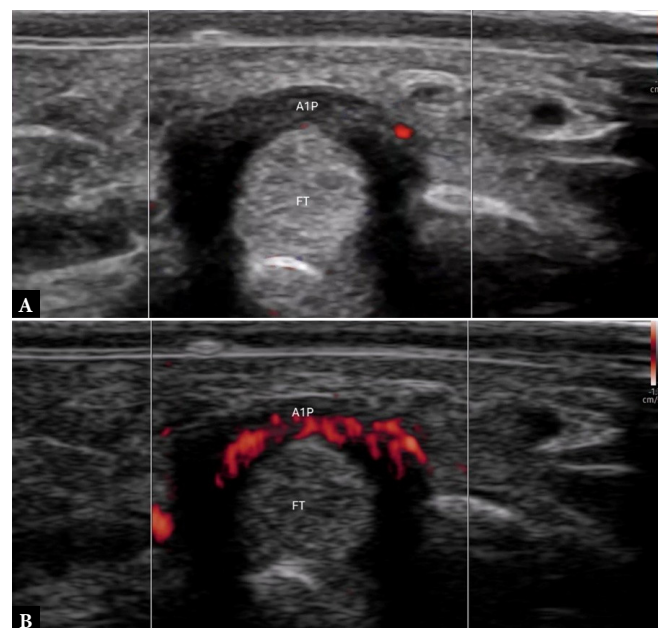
Trigger finger. Short-axis US scan of flexor tendons showing a single vascular spot on the Power Doppler image (A) and diffuse vascularity of the third finger A1 pulley on MVFI (B). FT – flexor tendons; A1P – A1 pulley
